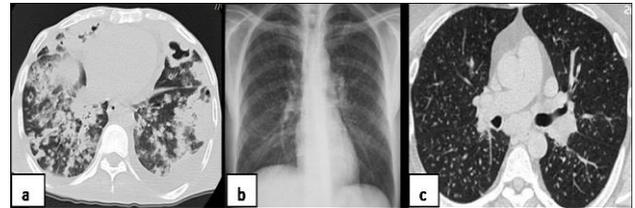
Active TB images (a) HRCT in a patient with TB shows fluffy alveolar opacities and ‘tree in bud’- centrilobular nodules suggestive of active disease (b, c) Chest radiograph PA view and HRCT of another patient shows multiple diffuse micronodules.
